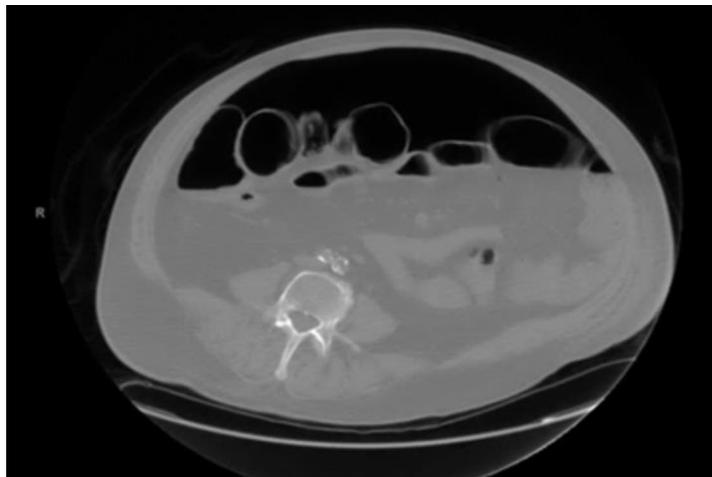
CT abdomen/pelvis shows large amount of pneumoperitoneum. Exact origin is uncertain. Dilated small bowel loop and dilated descending colon with air is seen with no sign of small or large bowel obstruction.
